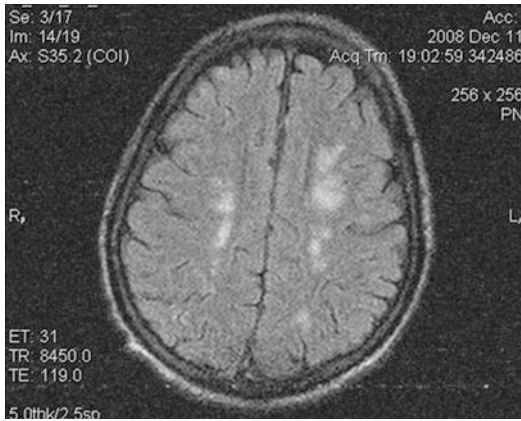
MRI showing abnormal signal intensity lesions in both cerebral hemispheres
